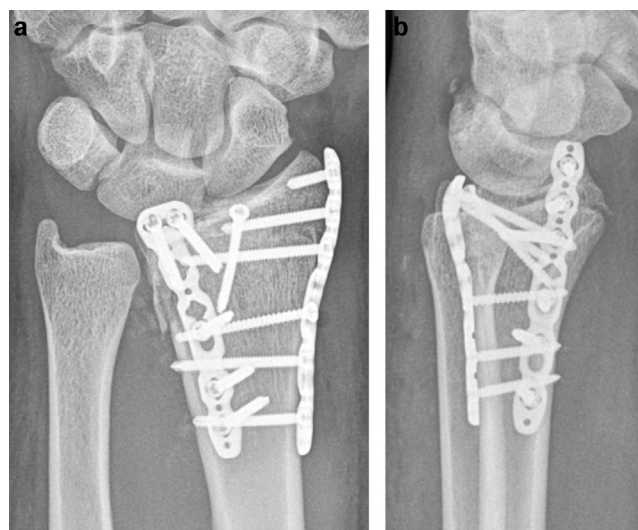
a: day 2 postoperative X-rays. A/P view: fracture stabilized with two plates and a free screw in the radial and ulnar columns of the distal radius as described by Rickli and Regazzoni [14] (a). Lateral view (b).
